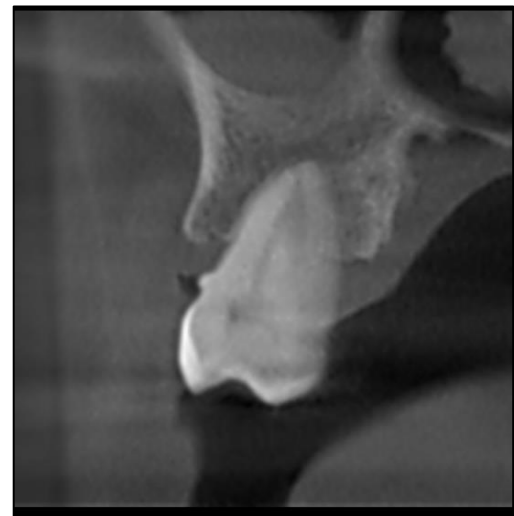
CBCT Cross-Sectional cut Showing that the Inferior Tongue Position makes it Clear to Identify the Palatal Soft Tissue
